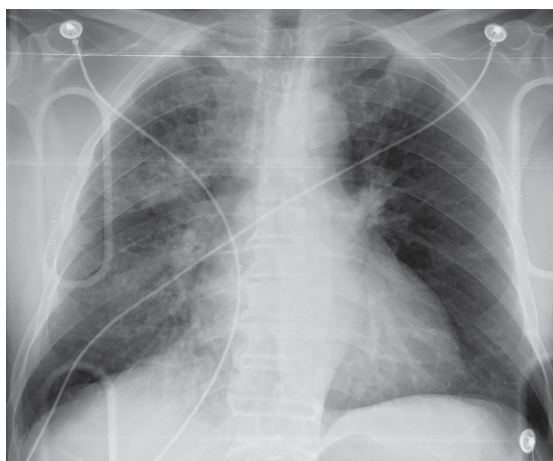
Posteroanterior chest X-ray revealing an alveolar-interstitial pattern in the right lung, with signs of ipsilateral volume loss.
